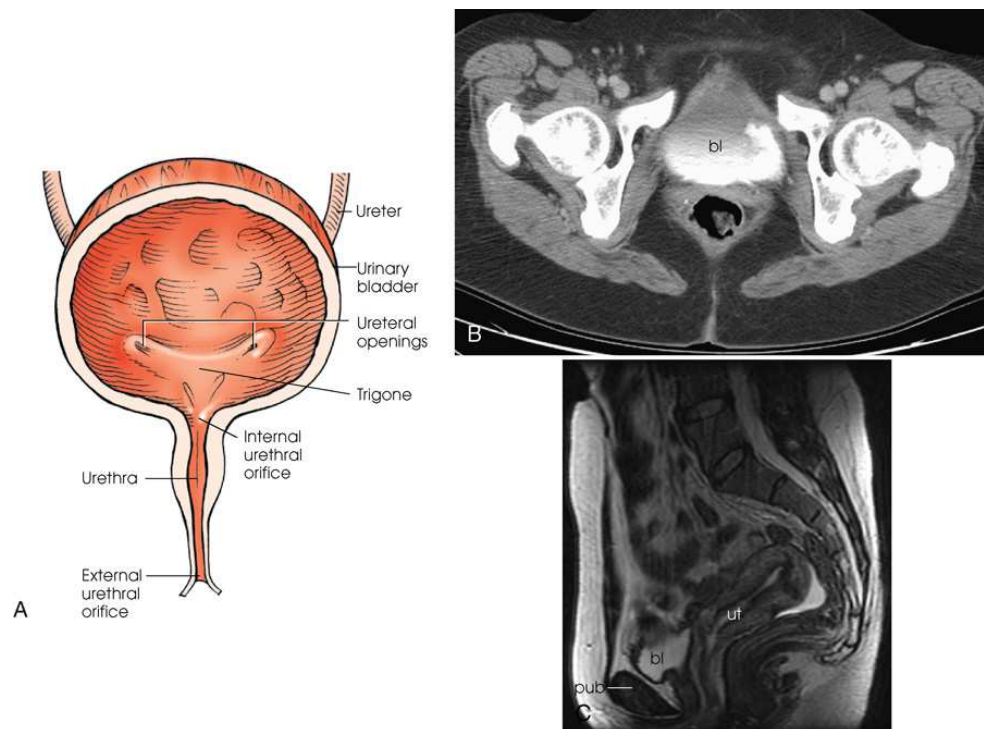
(A) Anterior view of urinary bladder. (B) Axial CT image of pelvis showing contrast medium–filled bladder (*bl*). (C) Sagittal MRI of female pelvis showing contrast medium–filled bladder (*bl*) and relationship to uterus (*ut*) and pubis (*pub*).
